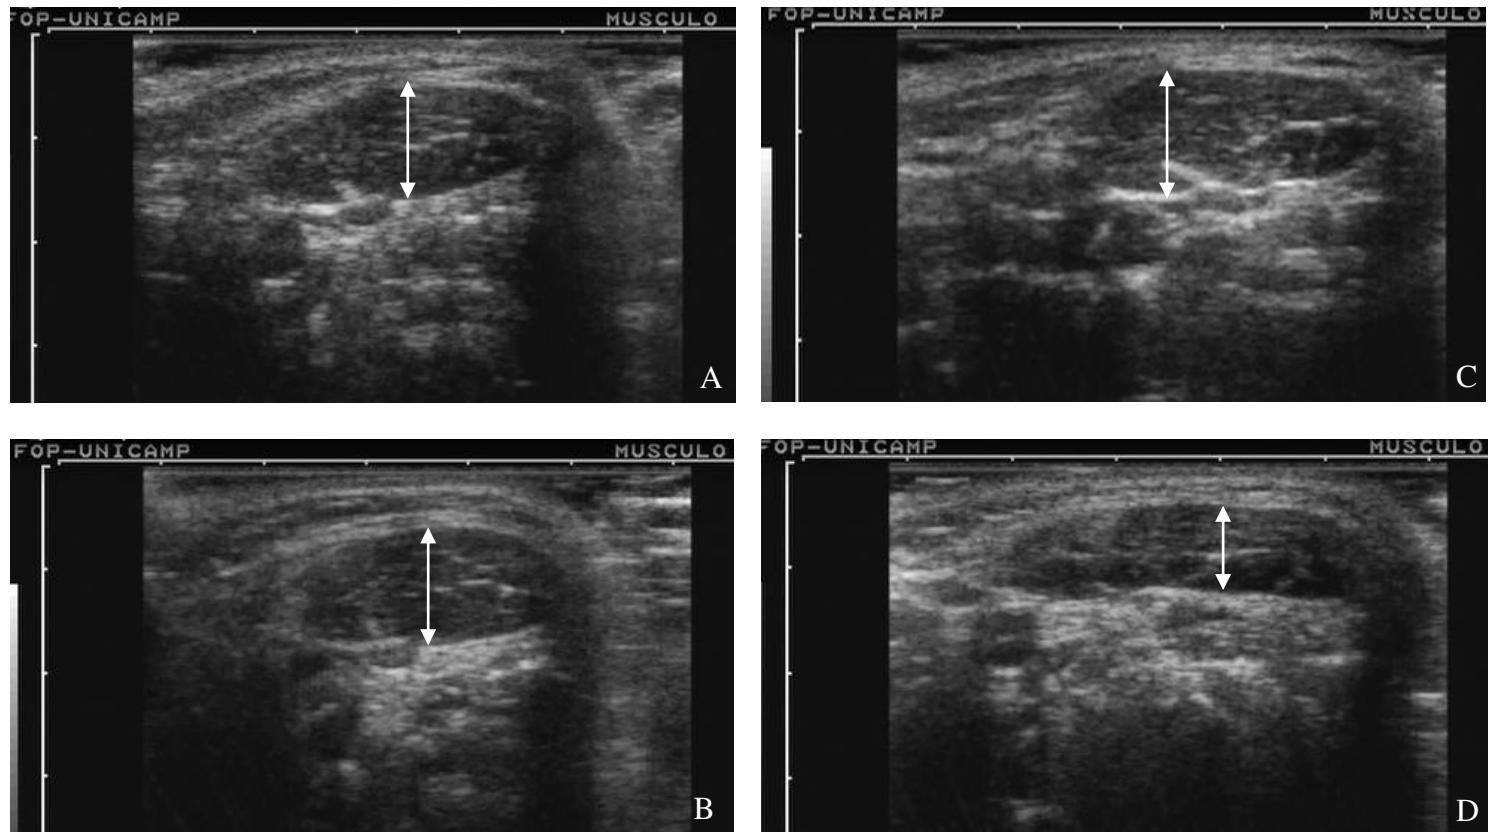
Ultrassonografia do músculo esternocleidomastóideo em repouso (A), no apertamento dentário (B), em flexão (C) e extensão (D) de cabeça. As flechas indicam a espessura muscular mensurada.
